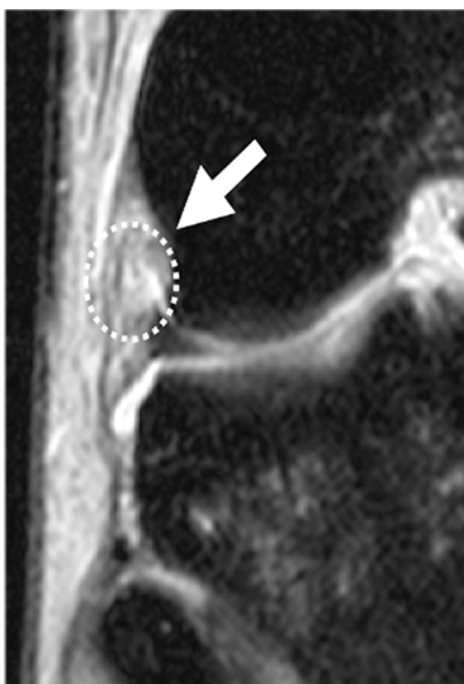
MRI image of an anterolateral ligament injury.
